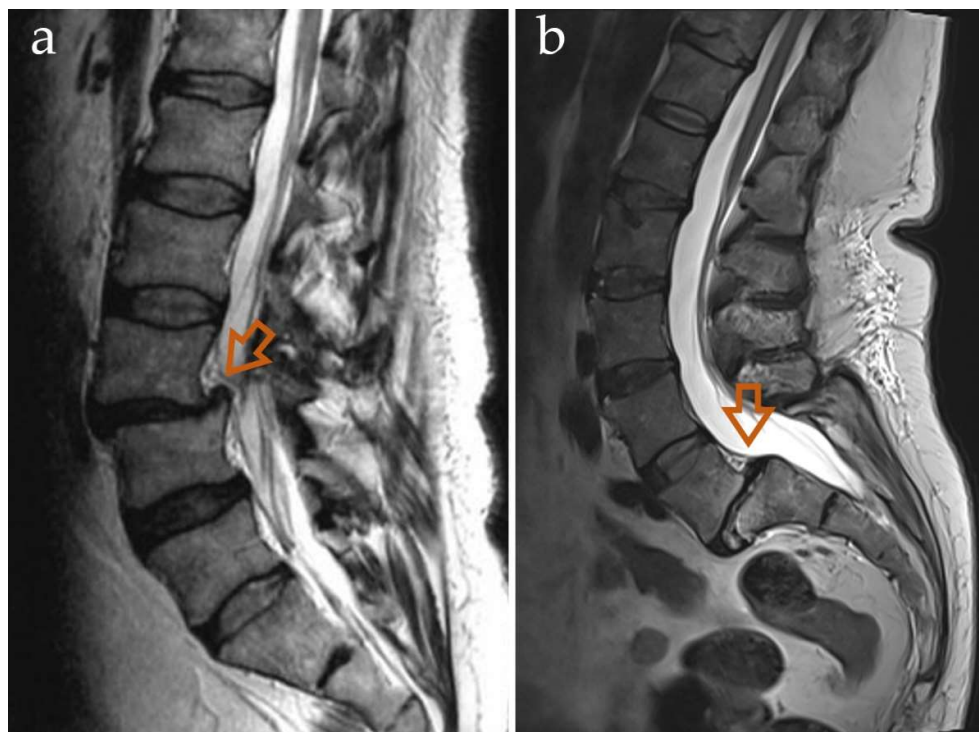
Sagittal images of MRI investigations in T2-weighted sequences, used for evaluation of the neural elements in two patients. A certain degree of slippage can be seen (orange arrows), but as the MRI is performed in a supine position, the slippage can be temporarily reduced, therefore the evaluation of the vertebral slip is best assessed on standing radiographs.
